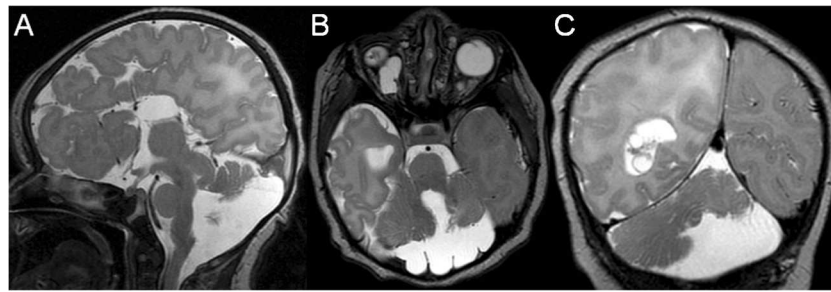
A 2-month-old infant with Aicardi syndrome. Midsagittal T2-weighted image (a) shows agenesis of the corpus callosum, tectal dysplasia, and cerebellar hypoplasia. Axial T2-weighted image (b) reveals right microphthalmia and cerebellar hypoplasia and dysplasia.
